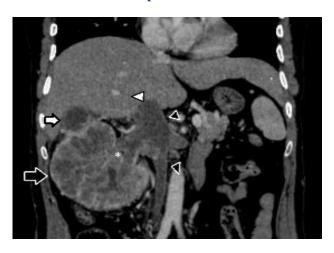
contrast enhanced CT scan coronal section showing locally infilterating right renal tumor.
